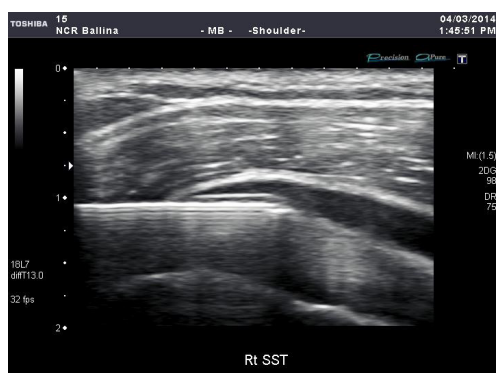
shows, using a real-time ultrasound technique, the needle placed in the exact location required. Precise needle positioning with millimetre accuracy is achievable.
